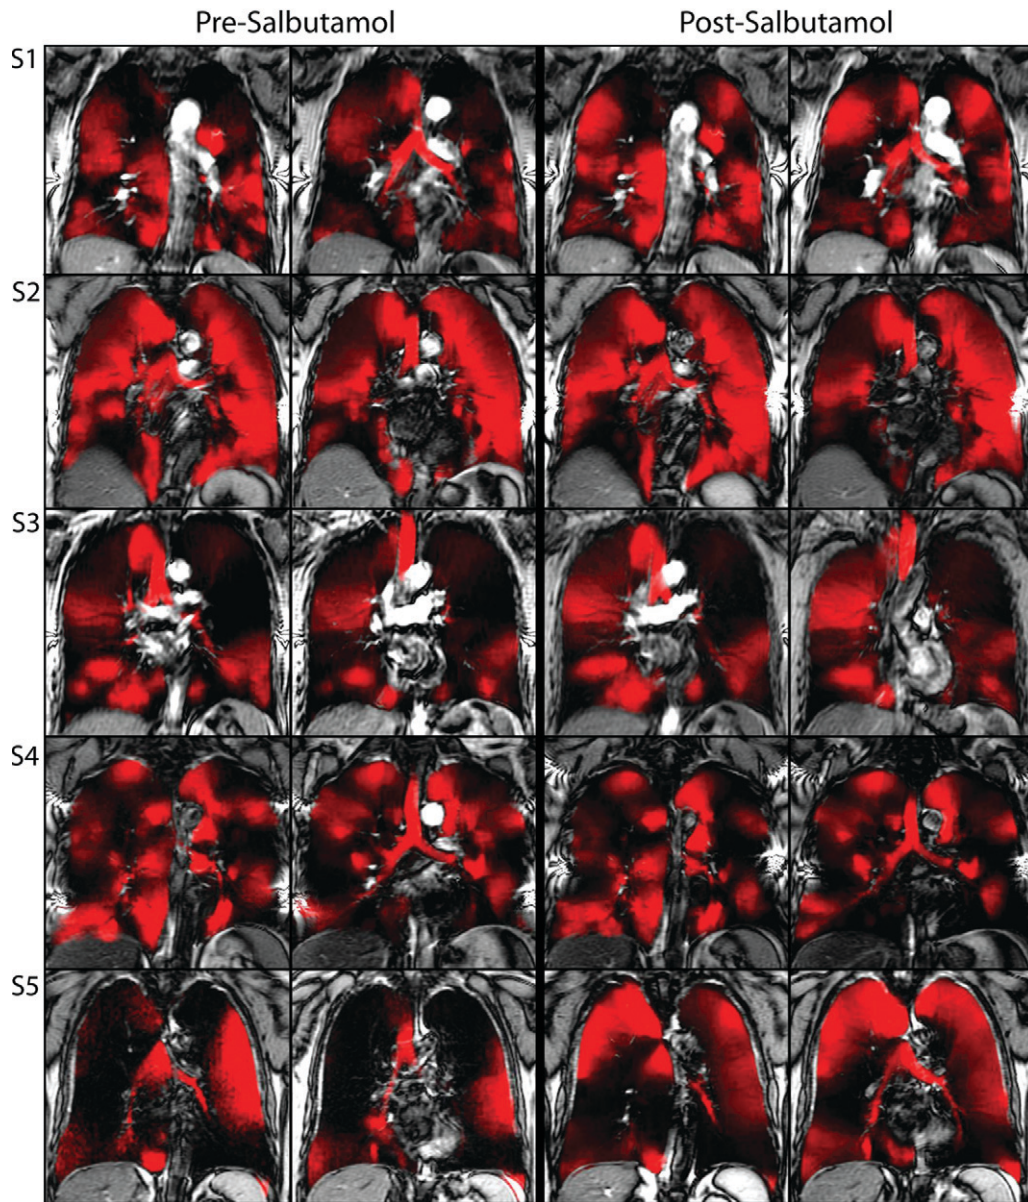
Pre- and post-salbutamol ^3He MR images (in red) registered to two center coronal thoracic ^1H MR images (in gray scale) for five representative patients with COPD. The patients in *S1* and *S2* had GOLD stage II disease, the patients in *S3* and *S4* had GOLD stage III disease, and the patient in *S5* had GOLD stage IV disease. The change in ^3He gas distribution after salbutamol is readily apparent in the right and left apical regions in *S1* and *S5* and in the right mid-apical region in *S3*, whereas there is little change visible in *S2* and *S4* for the two sections shown.
